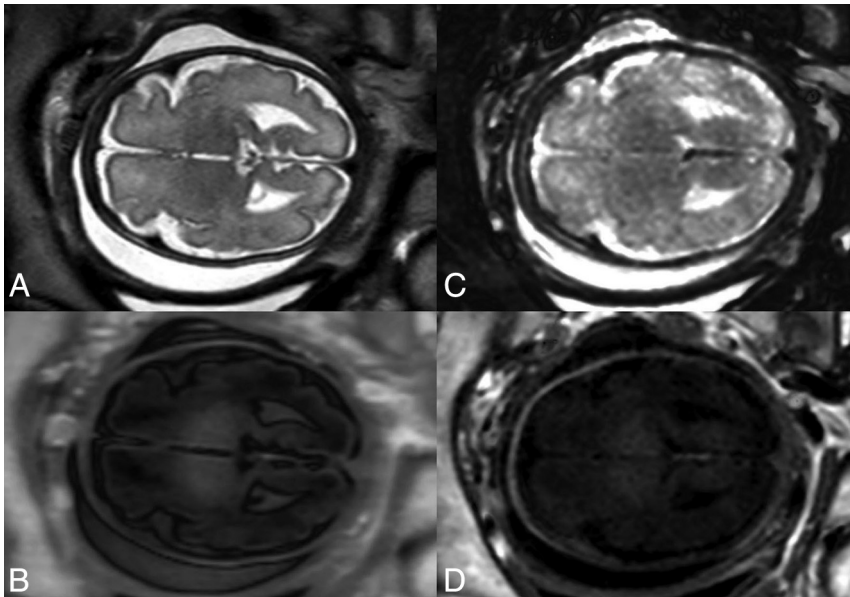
Conventionally acquired (A and B) and SyMRI-generated (C and D) fetal MR image data of comparable SIs: T2-weighted (A); snapshot inversion recovery (B); T2-weighted STIR (TR = 15000 ms, TE = 100 ms, TI = 300 ms) (C); and T1-weighted inversion recovery (TR = 2500 ms, TE = 10 ms, TI = 1050 ms) (D). Presentation of SyMRI-generated MR imaging contrasts based on the default software settings for TR, TE, and TI.
